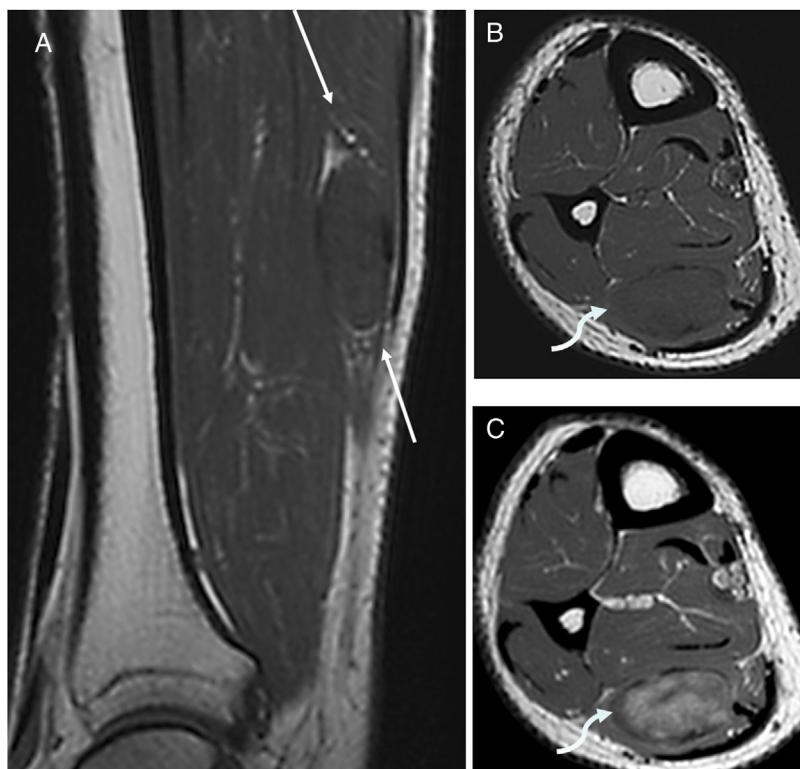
MRI. Sagittal T1-weighted spin-echo (A) showing an oval shape lesion, isointense with the muscle and the fat sign divided into the cranial and caudal poles of the lesion (arrows). Axial T1-weighted plane, with (B) and without (C) gadolinium, depicting an isointense lesion (curved arrow) with the contiguous musculature, but with the contrast medium the lesion enhances mostly centrally.
